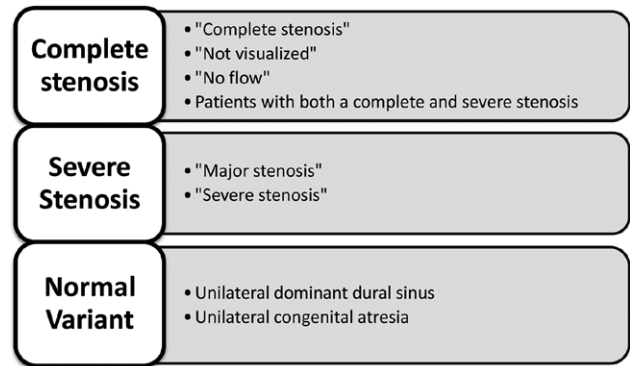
Definition of DVS stenosis based on radiographic findings.
